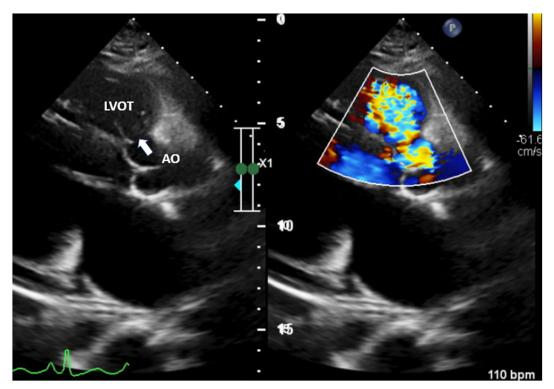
Two-dimensional TTE, parasternal long-axis diastolic view without (left) and with (right) color-flow Doppler, demonstrates a ruptured SOVA (arrow) with a left-to-right shunt from the aorta toward the right ventricle.
